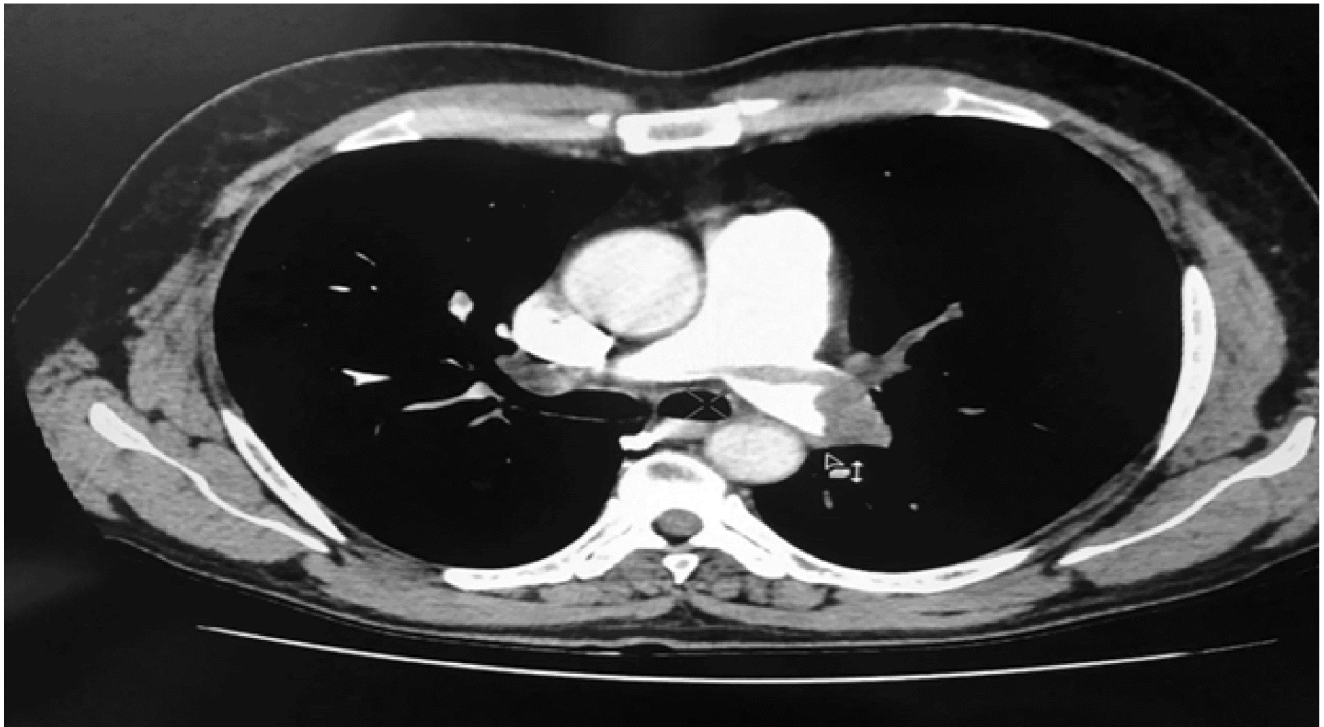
CT pulmonary angiogram axial view - showing large pulmonary thrombus in main pulmonary artery and left pulmonary artery.
